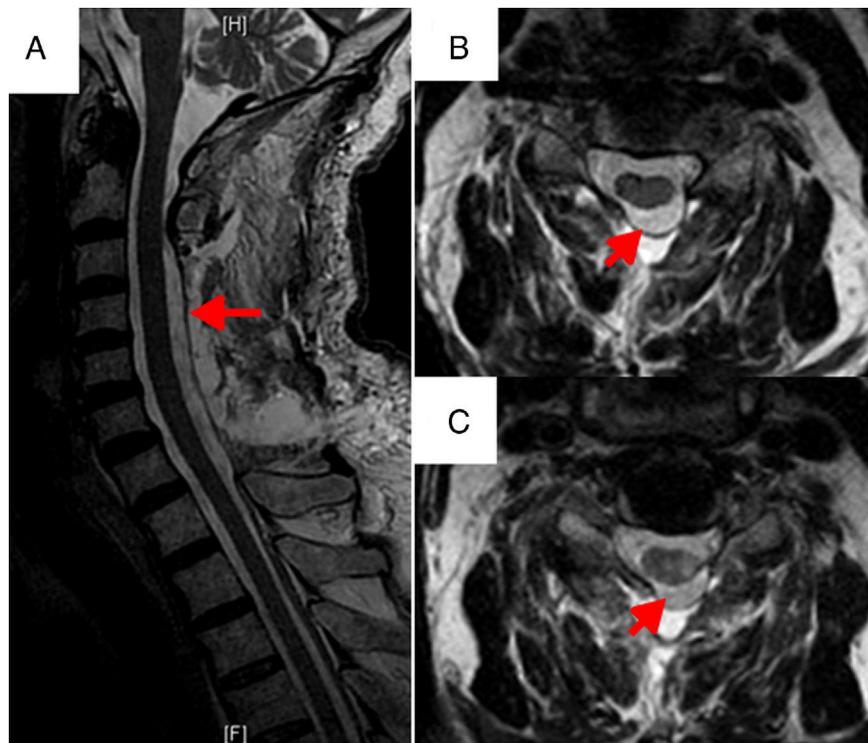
Cervical MRI scan performed 24 hours after surgery. Sagittal (A) and axial (B and C) slices showing adequate decompression of the spinal canal at vertebrae C3-C7 (arrows), with no sign of new blood collections or myelopathy at that level.
